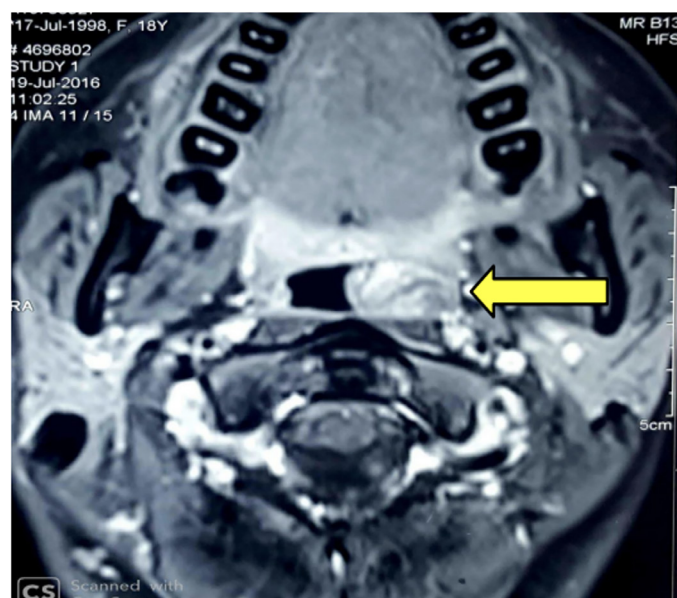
MRI shows high signal intensity T1W lesion arising from the left nasopharyngeal wall
